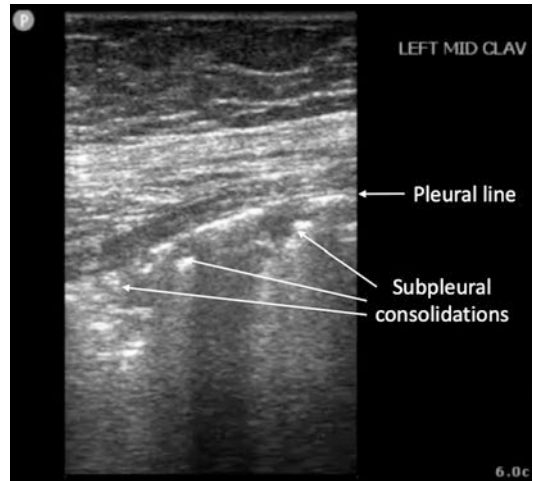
Linear probe 2D ultrasound image demonstrating subpleural consolidations
